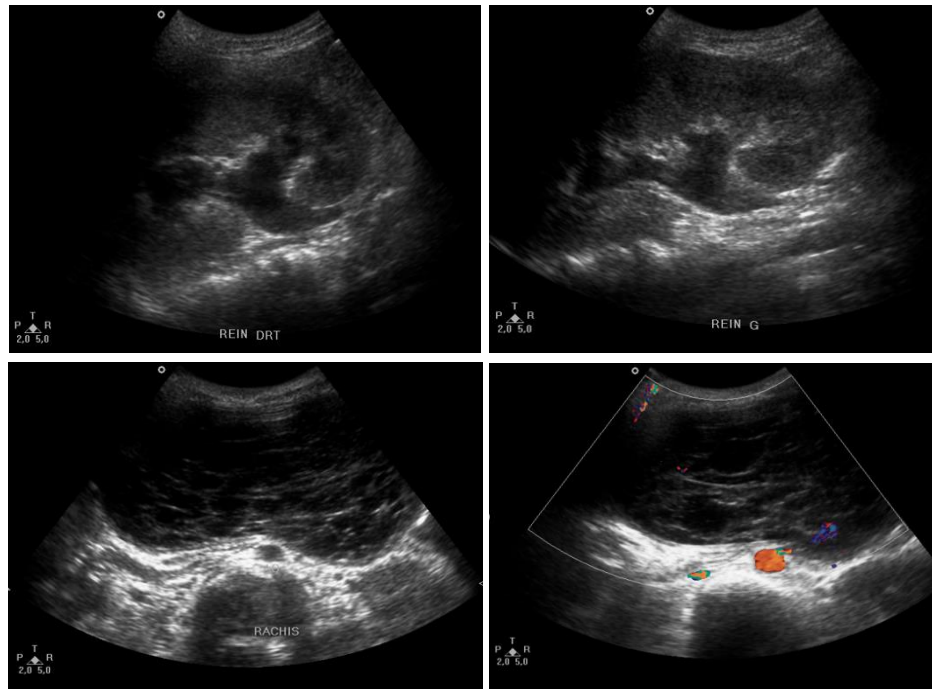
An abdominal ultrasound revealing a large and well-limited intraperitoneal fluid mass containing multiple septa, and tip of shunt catheter within it. This mass is in intimate contact with the rachis back and exerting a mass effect on the ureters with upstream dilatation.
